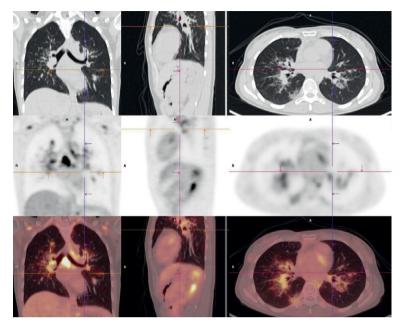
PET-CT patient 2: Suspicious relapse in hilar lymph nodes.
